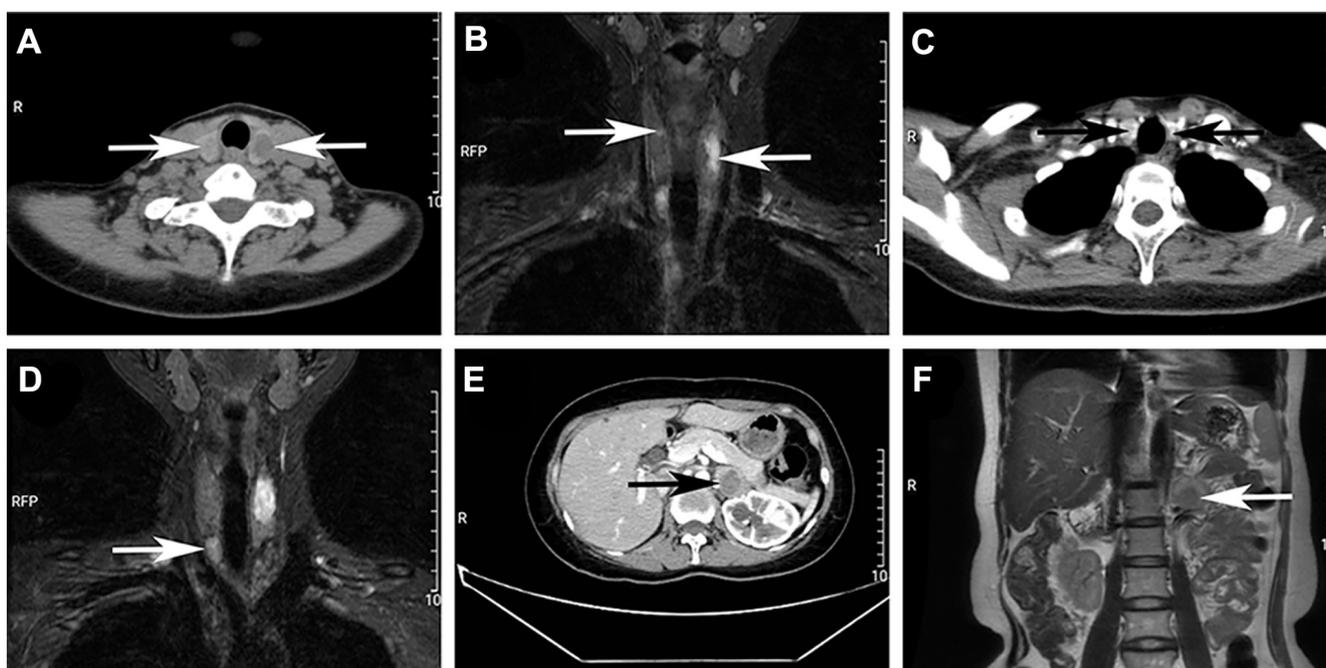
The imaging examination results of the proband (FAIII-6) with MEN2A-specific tumors. A, B) Neck computed tomography (CT)/magnetic resonance imaging (MRI) revealed multiple hypochoic nodules (left: 2.5 cm; right: 0.6 cm) in bilateral thyroid lobes. C, D) Neck CT/MRI indicated two hypochoic nodules (left: 0.6 cm; right: 1.5 cm) in lateral lower regions of bilateral thyroid lobes. E, F) Abdominal CT/MRI showed a left adrenal mass (3.3 cm).
